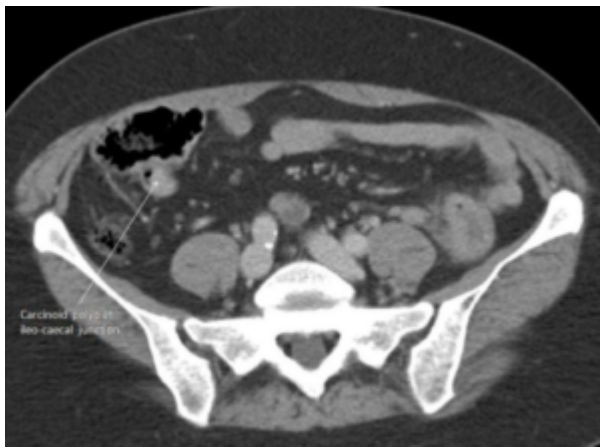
"CT scan image showing polypoidal lesion at ileocaecal junction" by Aslam MI, Salha IB, Muller S, Jameson JS. License: [CC BY 3.0](#)
